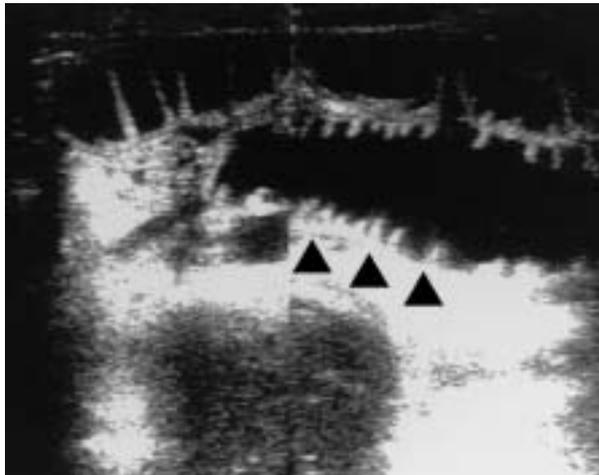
Ultrasonography of simple ileus
